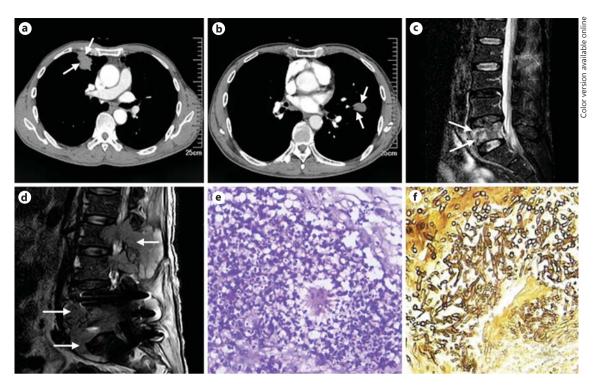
a Chest CT in December 2013 showed a 3×3 cm mass in the right middle lobe (arrows). b Chest CT in May 2014 revealed an emerging nodular lesion in the left lower lobe (arrows). c MRI showed bony destruction in L5 vertebral body (arrows). d MRI taken 1 month after the first lumbar surgery showed extensive
